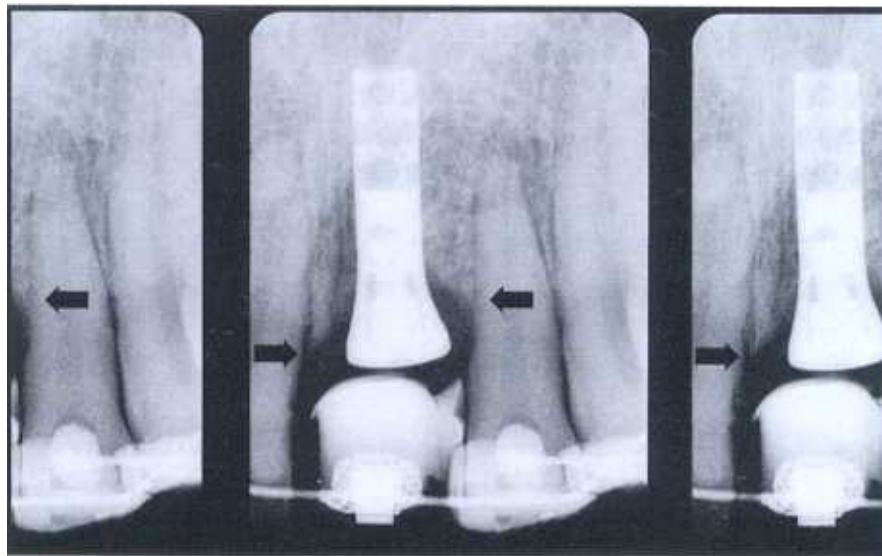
X-ray taken during the healing phase. Interproximal bone crest is now on the level of central incisors.
